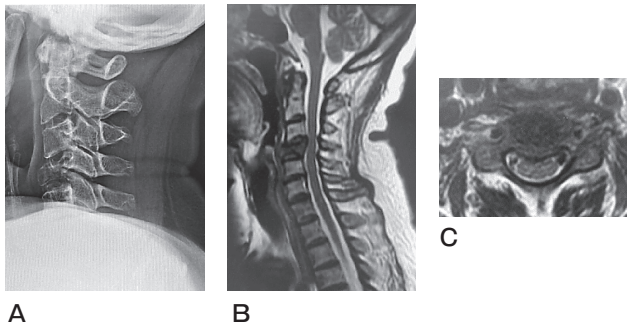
Preoperative cervical radiogram and MRI. A, The lateral cervical spine radiogram shows radiolucency of the C4 vertebra and a reduction of cervical lordosis; B, Preoperative MRI showing C4 vertebral destruction and mild spinal cord compression at the C4 level.
